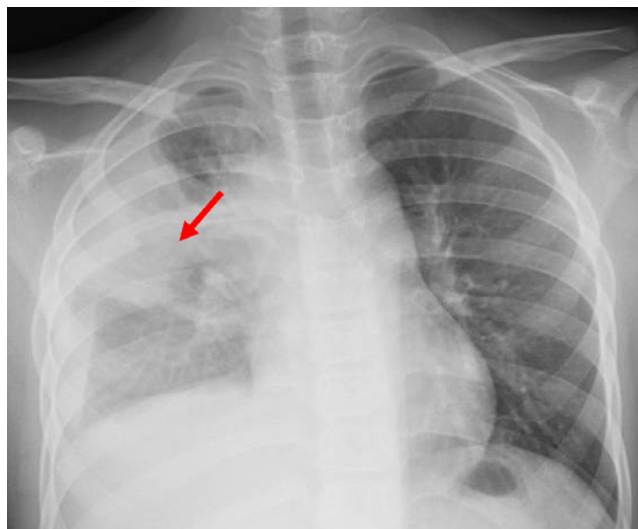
A greater opacity in the lower two-thirds of the right lung (arrow), as well as right pleural effusion, can be seen on a chest radiograph
